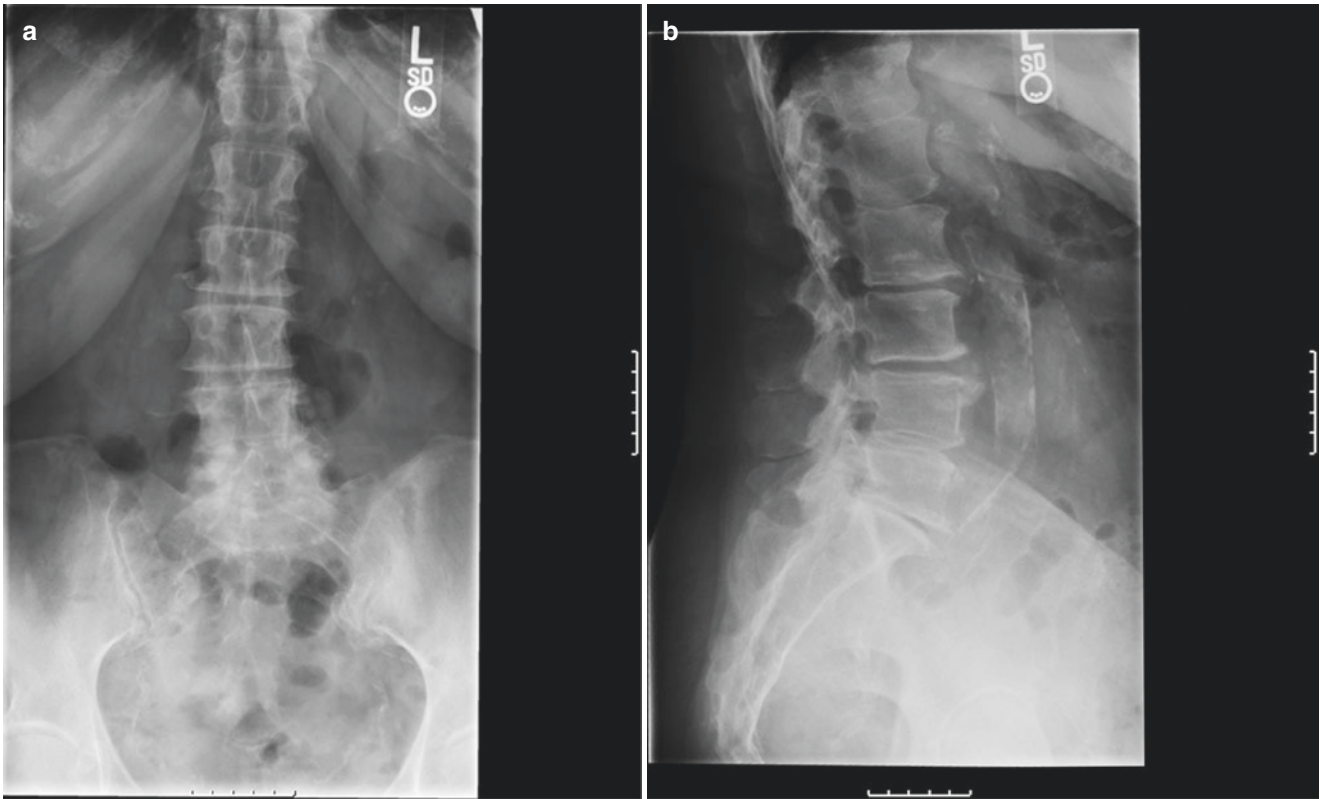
(a, b) Radiograph of osteoarthritis of lumbar spine. There is a mild curvature of the lumbar spine convex right with multilevel degenerative disk disease with disk space narrowing, endplate sclerosis, and osteophytes at L4–L5 and L5–S1
